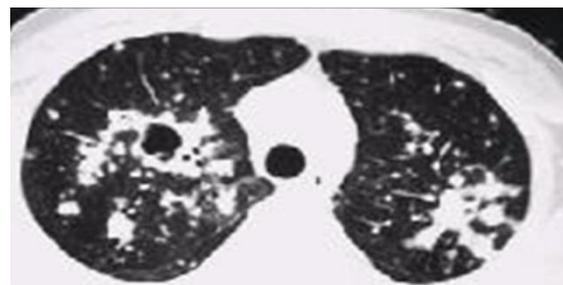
Showing HRCT image with a cavitary lesion and multiple conglomerated acinar nodules on right upper lobe and on left upper lobe with patchy areas of consolidations.
